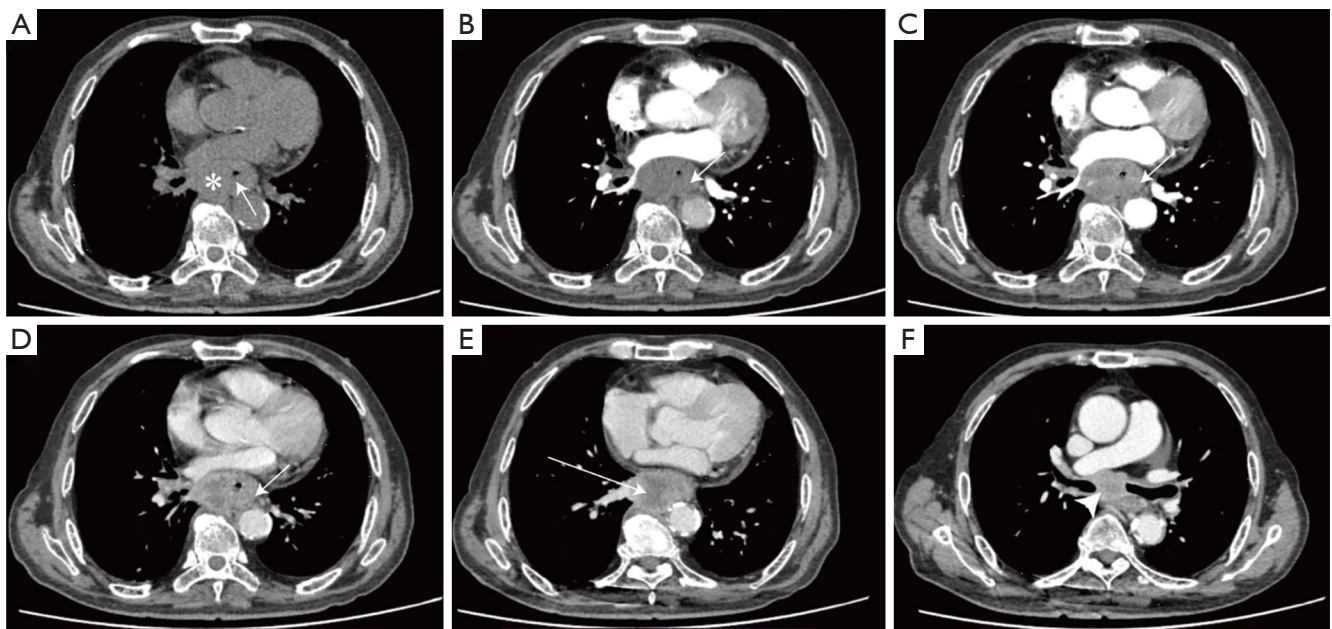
Plain and enhanced CT of the chest. (A) Pre-radiotherapy non-enhanced chest CT shows uneven circumferential thickening of the wall of the lower esophagus (stars) with isodensity (39 HU) and mass formation (white arrow). (B) Mild enhancement (45 HU) of the esophageal wall in the arterial phase (white arrow). (C) The esophageal wall still has increased enhancement (55 HU) in the venous phase (white arrow). (D) Significant strengthening (87 HU) of the esophageal wall during the delayed period (white arrow). (E) Localized hypointense area within the tumor after enhancement suggests possible tumor necrosis (white arrow). (F) Axial enhanced CT show enlarged lymph nodes with enhancement (white arrowhead). CT, computed tomography; HU, Hounsfield units.
